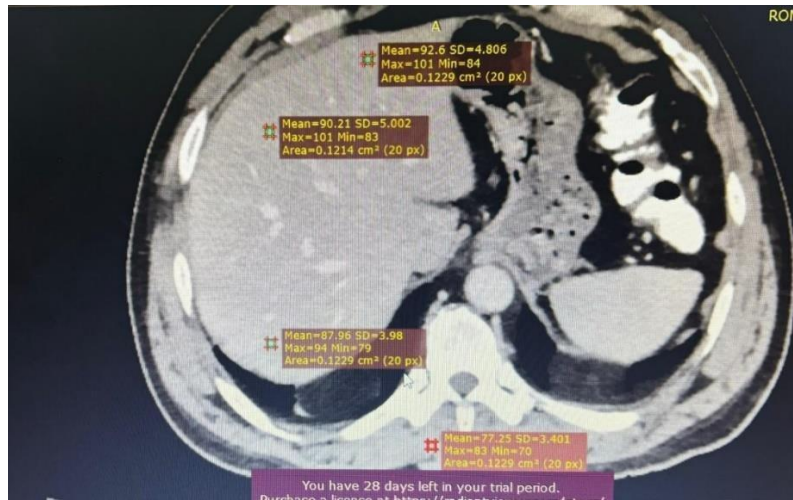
Axial view for liver CT scan for a patient with fatty liver disease.
